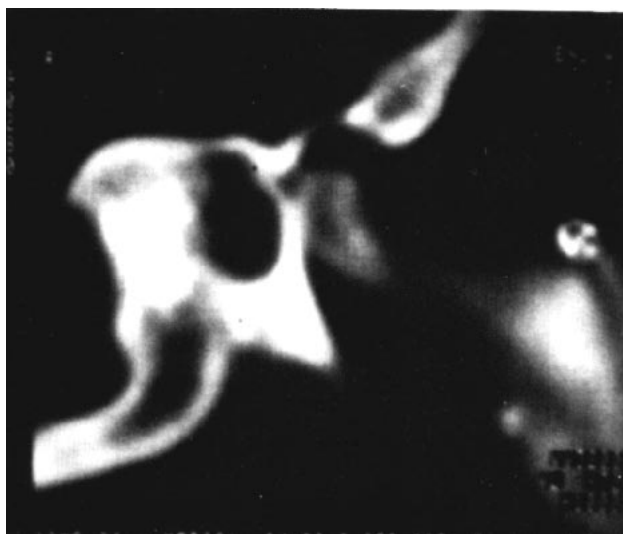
Our first CT study corrected for condylar angle, performed on a dried skull.
